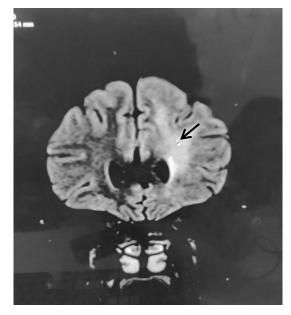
MRI T2 FLAIR, coronal cuts showing increased signal intensity in right Parietal region and bilateral Cerebellum (white arrowhead).
